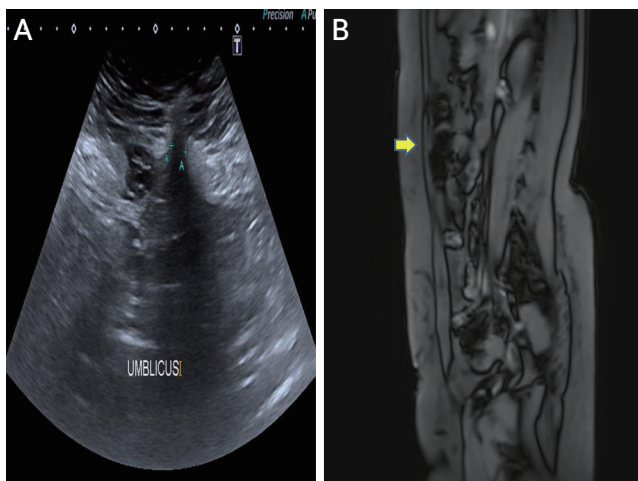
(A) Transabdominal ultrasonography of the retro-umbilical area. (B) MRI showing visceral adhesions behind the umbilicus (arrow). MRI: magnetic resonance imaging.
